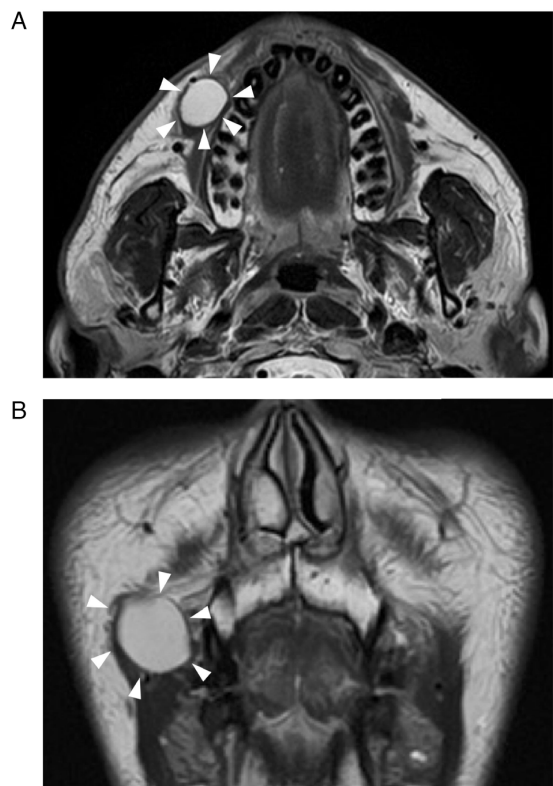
Results of MR imaging. MR T2-weighted imaging showed a high-signal area with a clear boundary and uniform interior, ~18 mm in diameter, within the right buccal mucosa (arrowheads). (A) Horizontal image. (B) Coronal image. MR, magnetic resonance.
